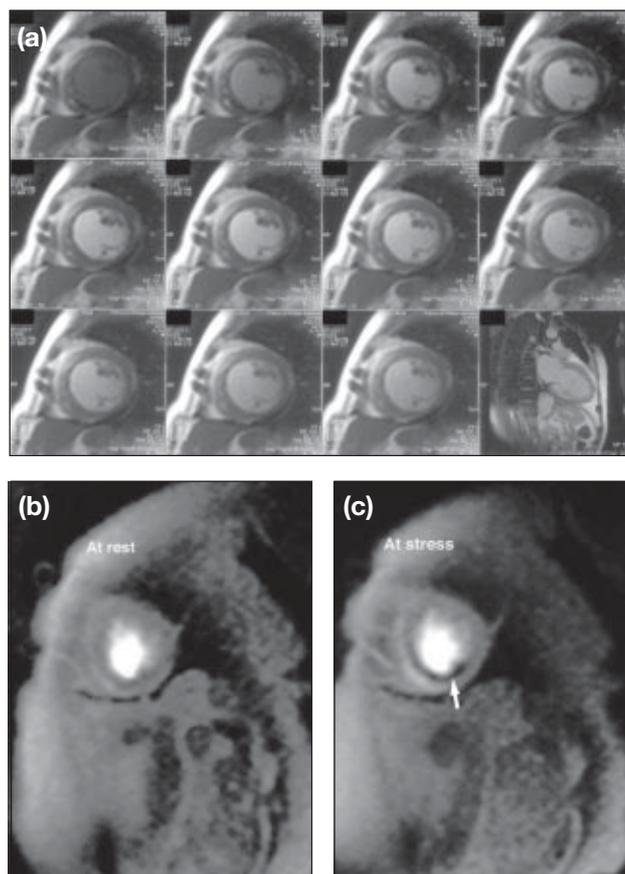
Magnetic resonance imaging at rest and during pharmacologically induced stress: (a) dynamic sequence of the left ventricle showing contrast entering the chamber of left ventricle and then subsequent enhancement of the myocardium; (b) perfusion at rest: short-axis view of the left ventricle shows normal perfusion of the myocardium; (c) perfusion during stress: short-axis view shows hypoperfusion of the inferior wall (arrow)
